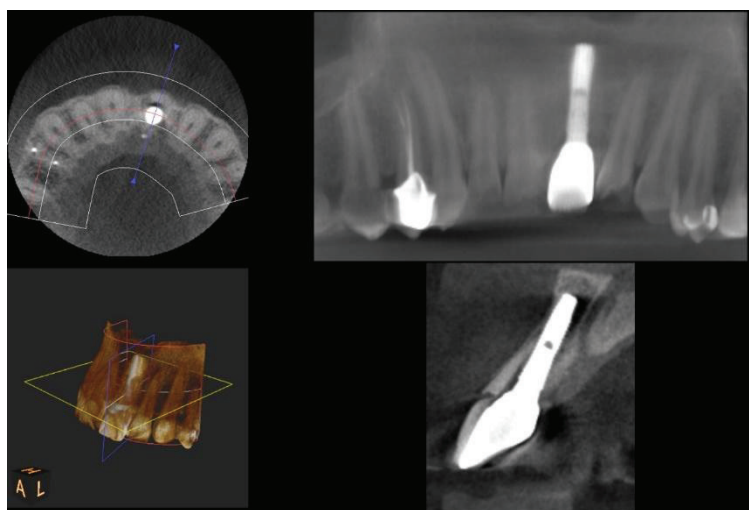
One year follow up CBCT of the implant.
